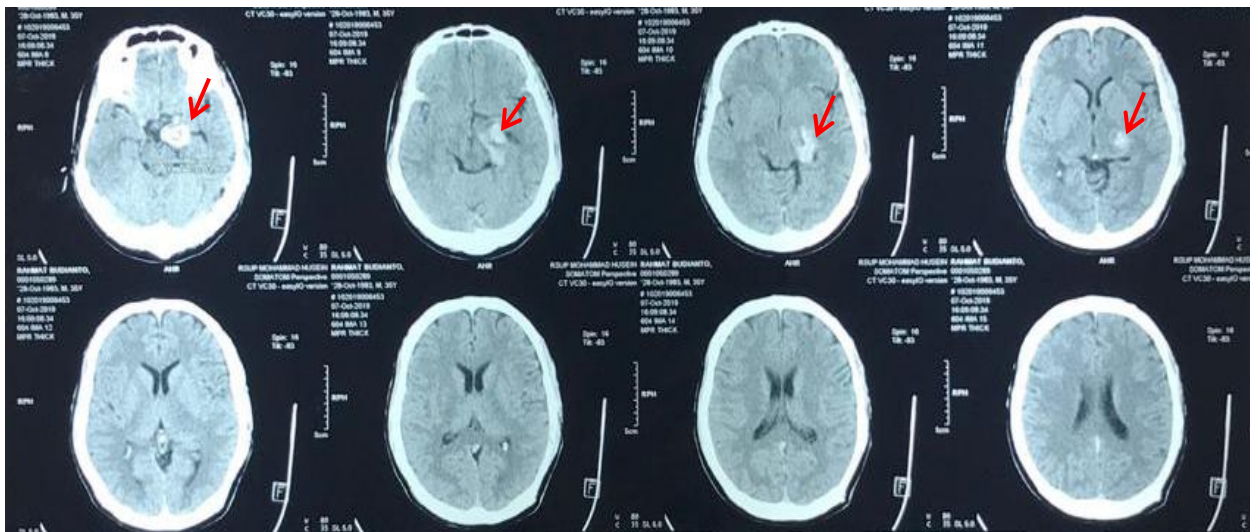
A head-contrast CT scan showed lobulated lesions, with enhancement post-contrast on the left suprasellar region (red arrows)
